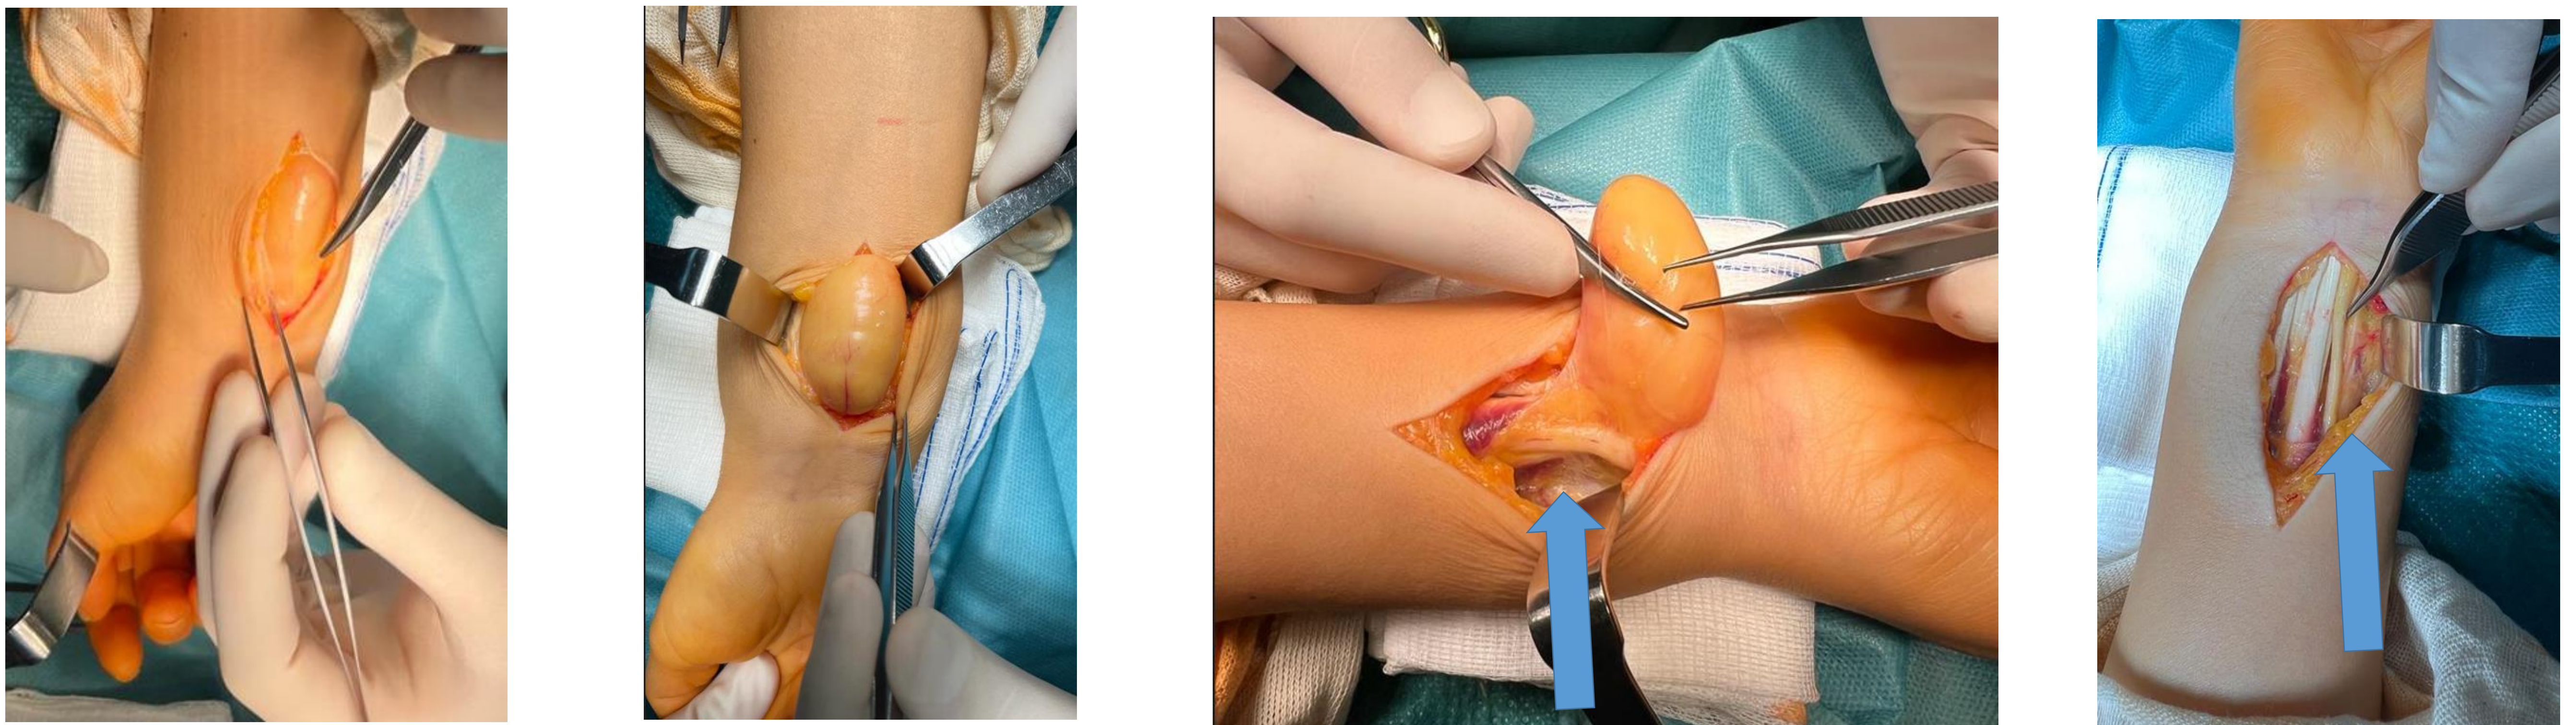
(MRI): Surgical dissection of the lipoma. Arrow – median nerve.
